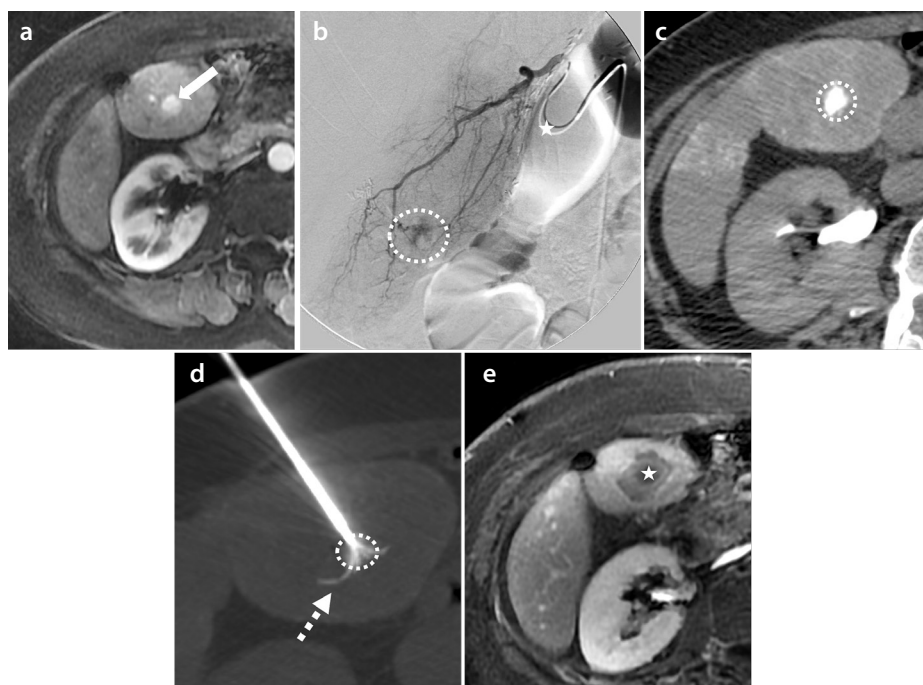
Tagging of a liver metastasis from a neuroendocrine tumor by selective intra-arterial iodized oil injection and subsequent radiofrequency ablation (RFA) in a 56-year-old female. Panel (a) shows an arterial phase of the pre-treatment magnetic resonance imaging (MRI) with a hypervascular tumor measuring 12 mm in segment IVb (white arrow). Panel (b) shows the selective angiography with a microcatheter (white star) placed in the segment IVa artery and a tumor blush (dotted circle). After injection of 2 mL of iodized oil, the tumor showed strong accumulation [dotted circle panel (c)]. Subsequently, an expandable RFA needle (LeVein, Boston Scientific, Natick, MA, USA) (dotted white arrows) was placed under computed tomography guidance covering the entire tumor [panel (d)]. Panel (e) shows a contrast-enhanced MRI six months after treatment without evidence of tumor recurrence (white star).
